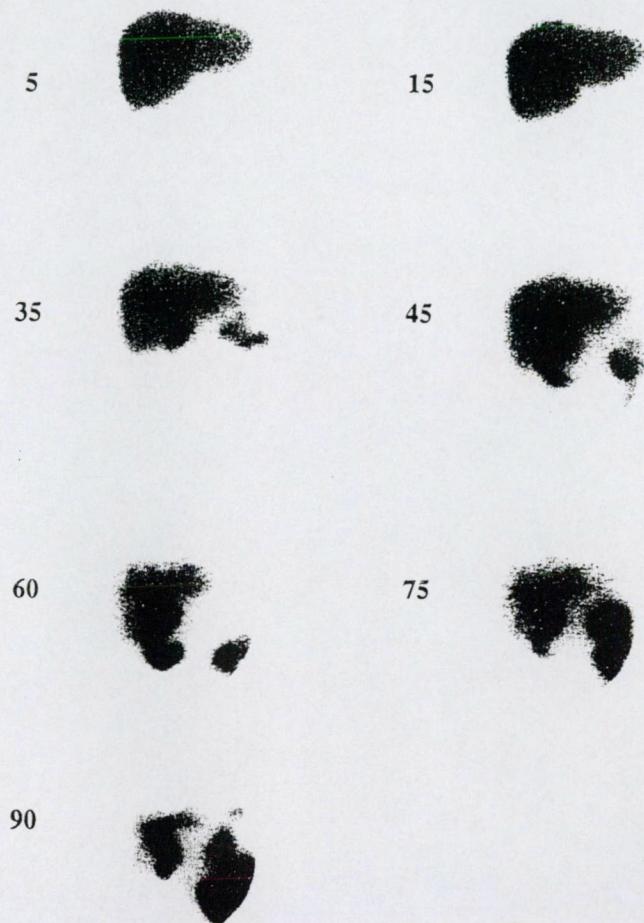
Hepatobiliary scintigram in a patient with a negative prostigmine-morphine test. The CBD was prominent, but a clear decline in activity was detected after 45 min, and the duodenal appearance time was normal (35 min)
